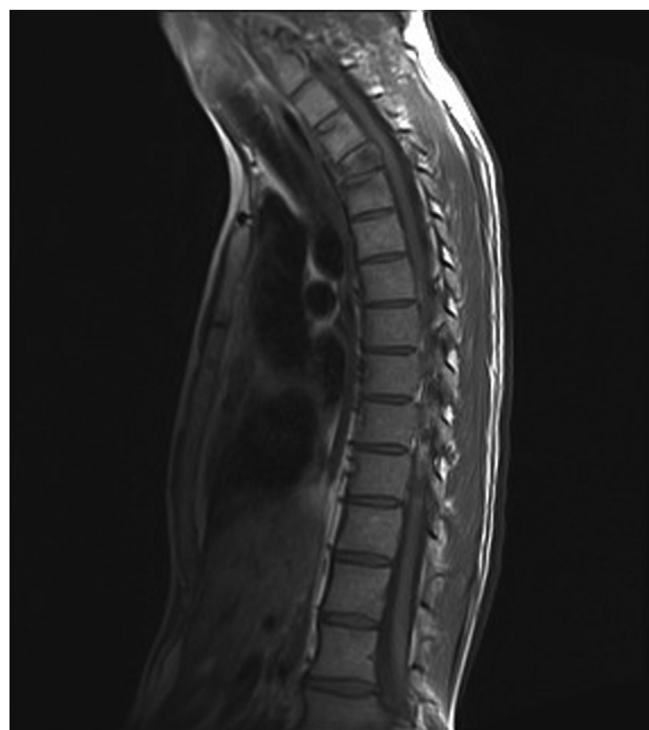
The MRI shows a T3 burst fracture with multilevel enhancing marrow signal lesions.
